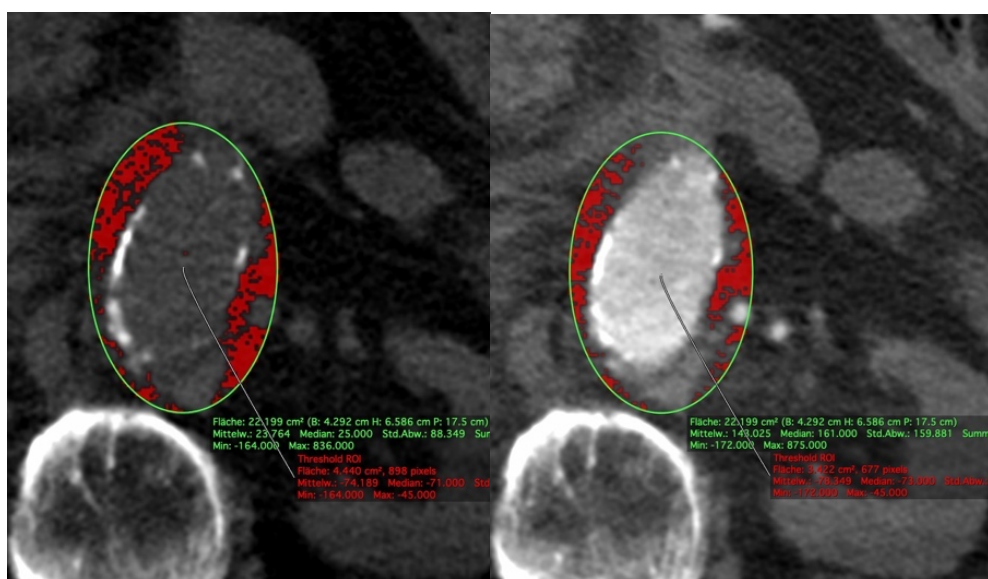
Non-circular periaortic ROIs. They posed no limitation for the present study, since identical segments of periaortic tissue were compared in the two CT phases.
